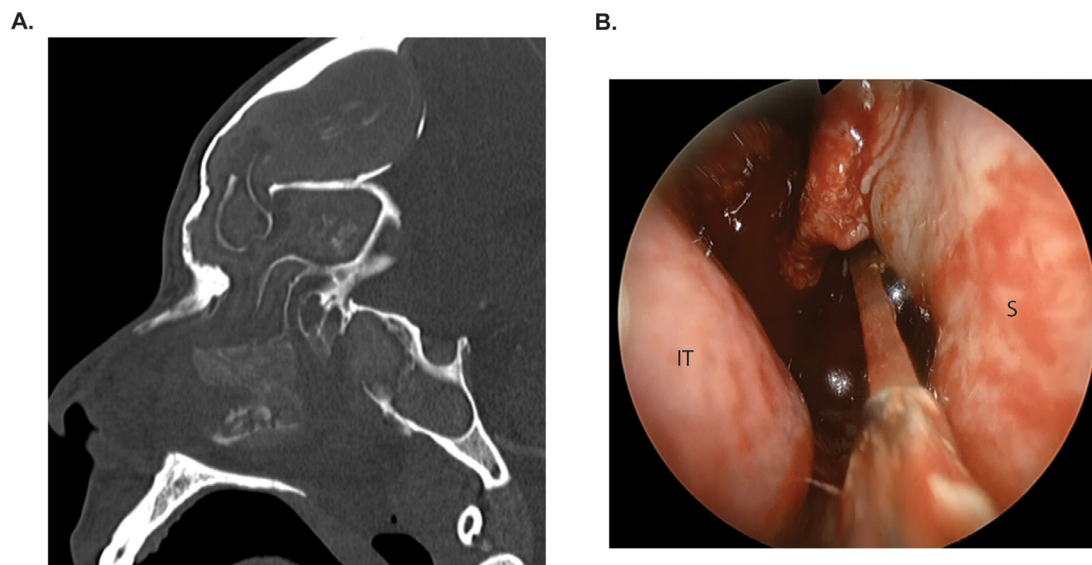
Characteristic computed tomography and nasal endoscopic image of allergic fungal rhinosinusitis. (A) Representative sagittal computed tomography sinus image highlighting expansion of frontal and ethmoid sinuses and “double-density” sign within affected sinus cavities. (B) Nasal endoscopic view of right nasal cavity revealing sticky nature of eosinophilic mucin found within diseased sinus cavities. IT, inferior turbinate; S, septum.
